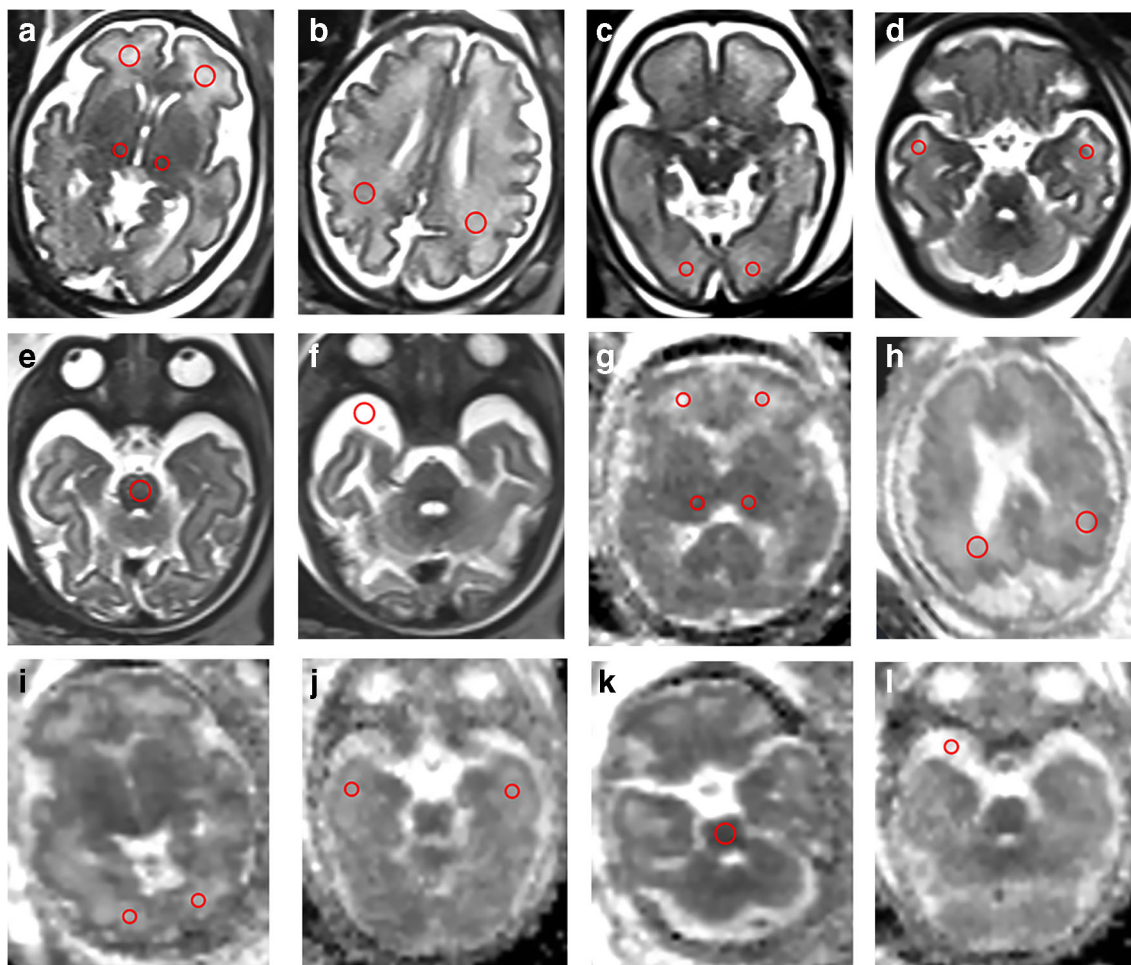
Positioning of the region of interest in 28–35 weeks gestational age fetuses. a–f Axial T2-weighted imaging (T2-WI). g–l Axial apparent diffusion coefficient (ADC) maps from diffusion-weighted imaging. The regions of interest are positioned in the right and left frontal white matter
